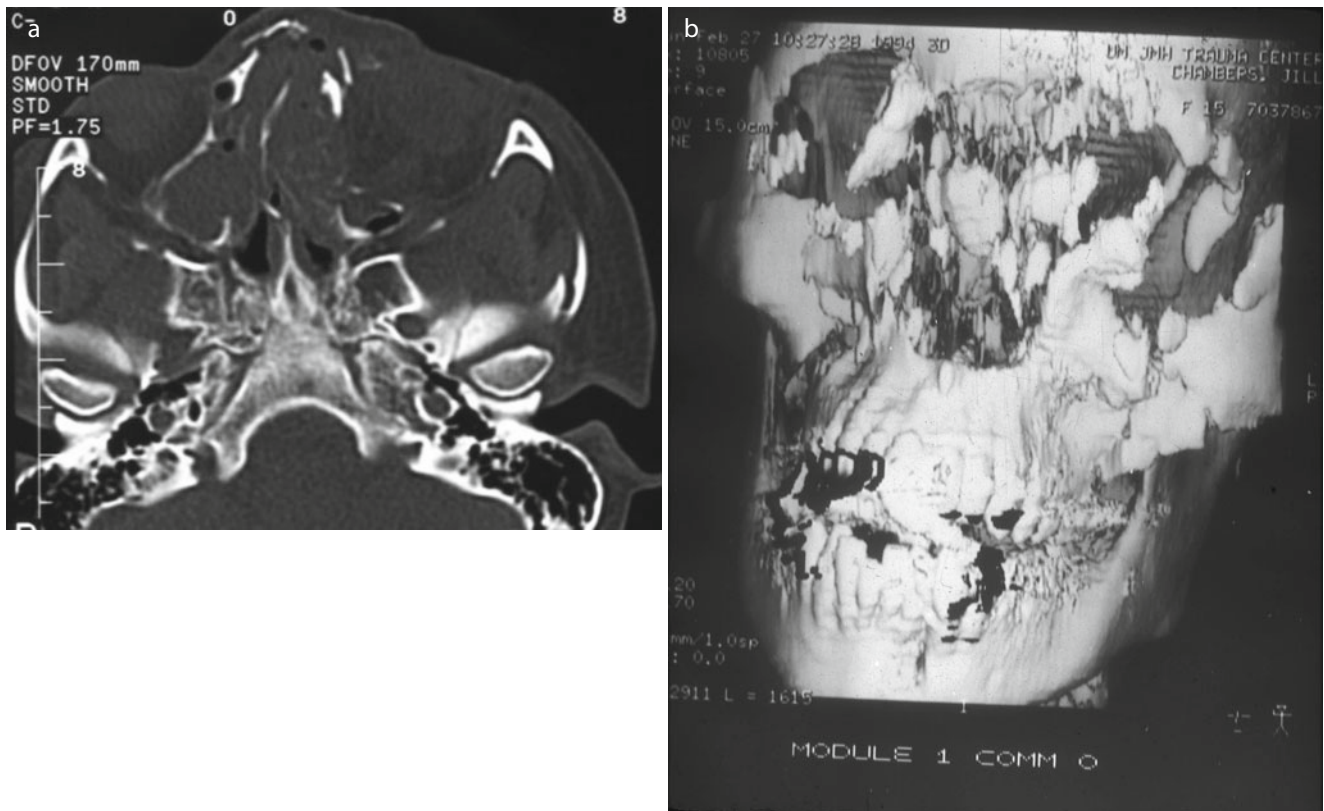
Axial CT section and 3D CT reconstruction demonstrating NOE fractures [Case #1 (*left*) and Case #2 (*right*)]
